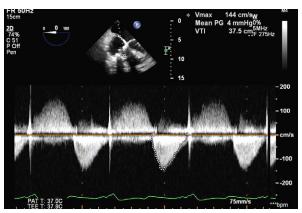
Transthoracic echocardiogram shows improvement of the transvalvular gradient to 4 mmHg after Melody valve implantation.
